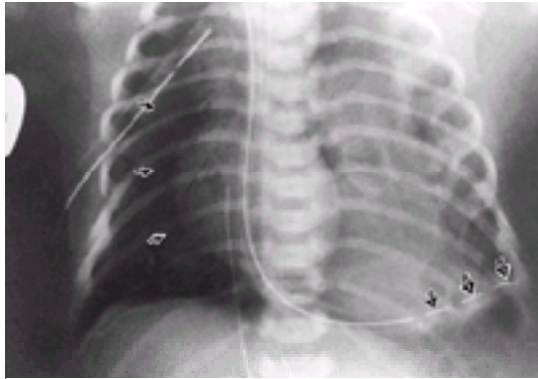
Chest radiograph of neonate with severe respiratory distress reveals a left-sided diaphragmatic hernia with contralateral pneumothorax and collapse of the right lung (closed arrows). There is marked gaseous distension of the intestinal contents in the left hemithorax and the nasogastric tube is visualized in the left chest (open arrows).
